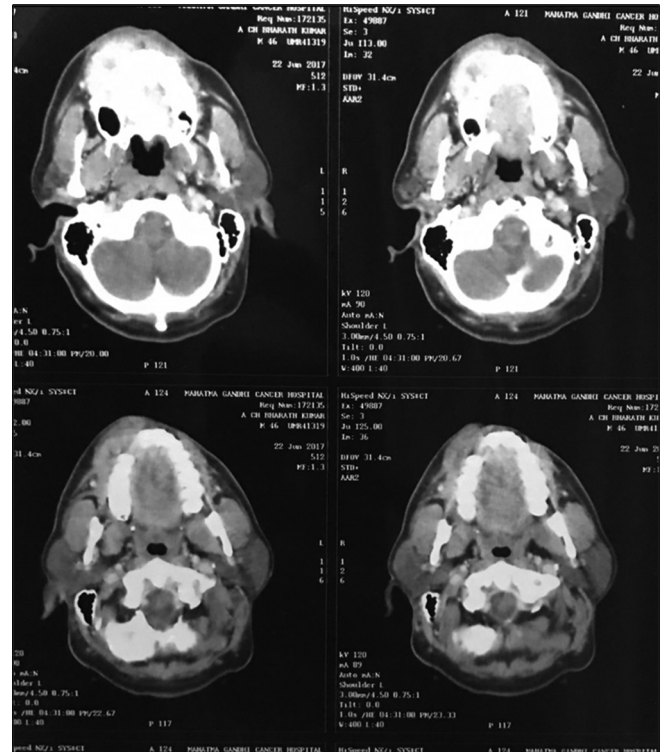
Computed tomography scan of paranasal sinuses
